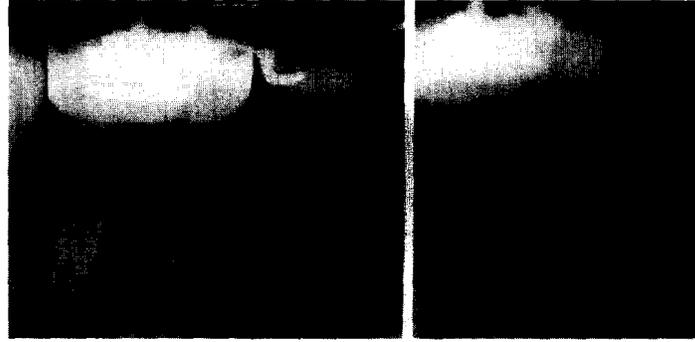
Radiographs of second premolar and first molar 3½ months after extraction of first premolar shown in Figs. 2 to 4. Normal contact relationship has been attained by orthodontic treatment. Conditions on mesial surface of first molar during eruption had probably been similar to those on distal surface of first premolar (Fig. 3). Left radiograph shows angular bone defect facing mesial surface of first molar. Right radiograph shows probe inserted 4.5 mm. below cemento-enamel junction, indicating loss of attachment of same magnitude as seen in Fig. 3. (Roentgenographs slightly retouched to bring out contrast in reproduction.)
